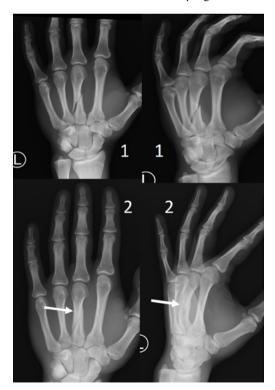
(1) Spiral fracture of the third metacarpal bone at presentation, treatment without any immobilization. (2) X-ray of the patient at the 12 months. Note excellent union of the fracture.
